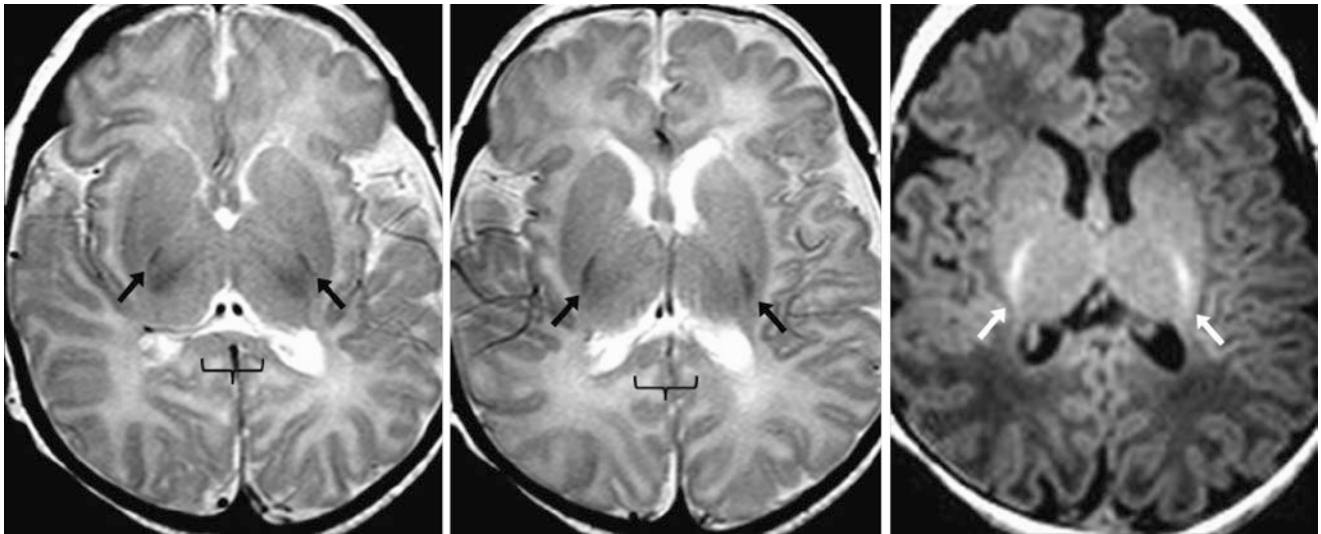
A 21-day-old term neonate had a normal 3T MRI with SE T2WIs (left and middle) and GE T1WI (right). The PLIC (arrows) is visualized on both sequences and appears clearly myelinated. The HC is not included on these images because of angling. Note possible early myelination within the callosal splenium on SE T2WI (brackets)
